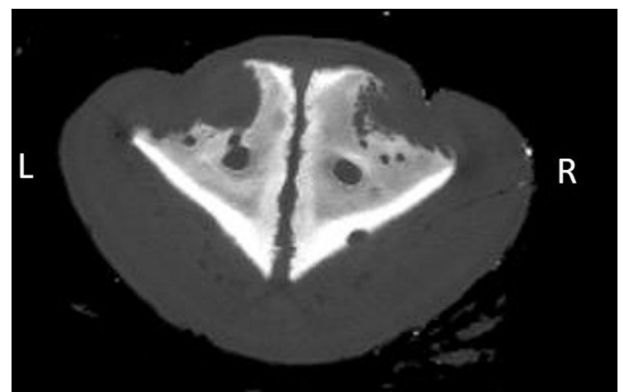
Transverse CT image showing empty alveoli L2 (left), with mild remodelling, and R2 (right), with moderate remodelling.
